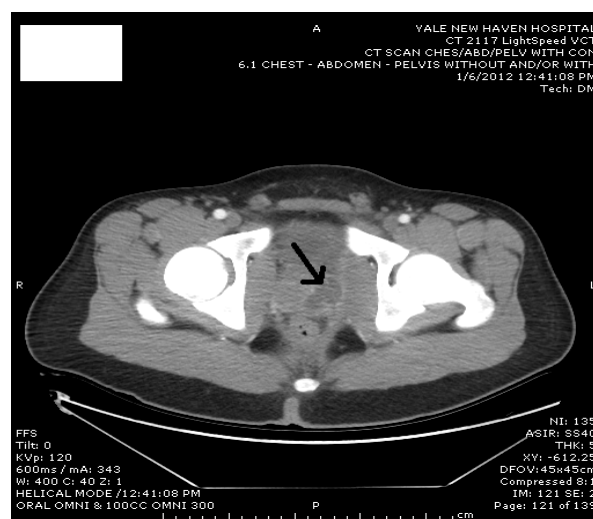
Abdominal pelvic CT scan demonstrating prostatic abscess (arrow).
